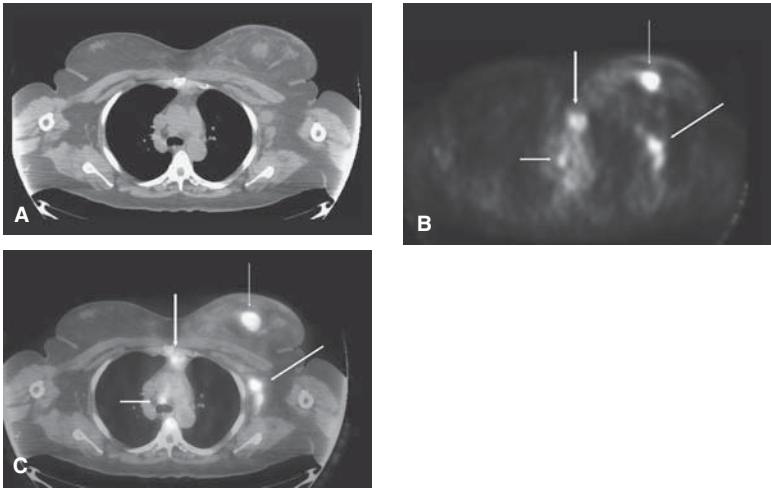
A 50-year-old woman presenting with inflammatory breast cancer. Left breast mass and palpable axillary lymph nodes. (A) Transaxial CT of the chest shows the left breast mass. (B) Transaxial PET at the same level shows intense FDG uptake in the breast mass (thin vertical arrow), in internal mammary lymph nodes (thick vertical arrow), in the left axillary lymph nodes (thick diagonal arrow), in the paratracheal lymph nodes (horizontal thick arrow), and in the soft tissues of the left breast. (C) Transaxial fusion of PET and CT co-localizes the same abnormalities described in (B).
